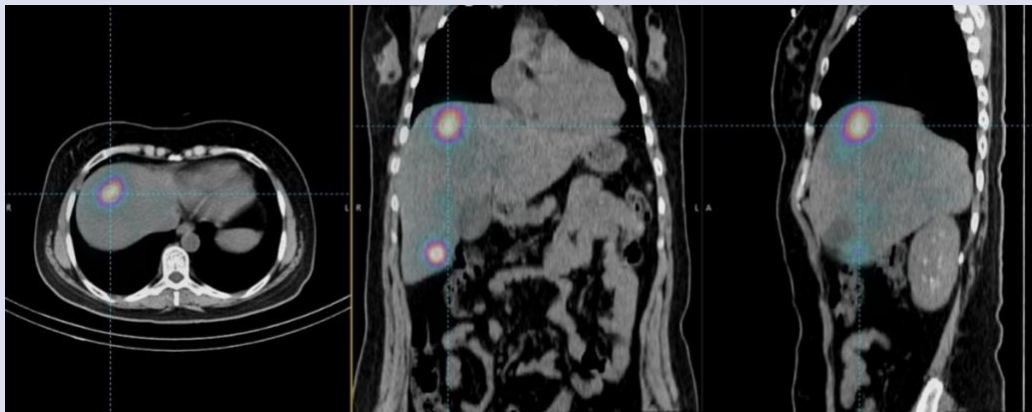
Short-axis, coronal, and sagittal cross-sectional views of the tumor in the liver from left to right in a SPECT/CT image taken after the administration of ^{99m}Tc-MAA in a patient. Yellow, blue, and red colors respectively indicate liver, lung, and tumor.
